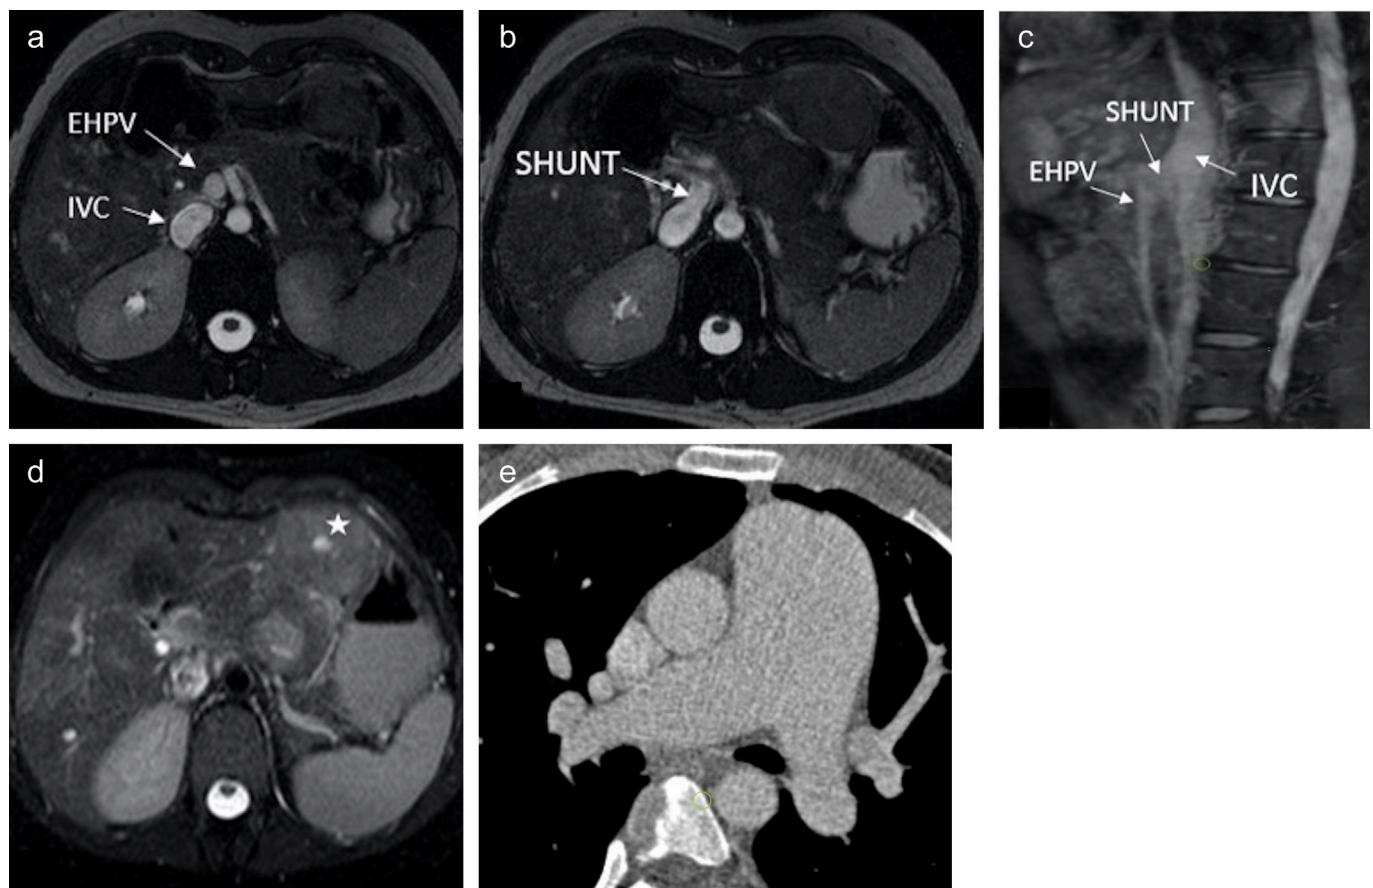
a-e. Type 1b Abernethy malformation with hepatic focal nodular hyperplasia and pulmonary hypertension. Consecutive axial balanced turbo field echo magnetic resonance (MR) images from inferior (a) to superior (b) show the EHPV draining into the retro hepatic IVC. No intrahepatic PV branches are seen. Sagittal MR angiography image (c) shows a shunt directly connecting EHPV to retro hepatic IVC. T2-weighted axial MR image (d) shows multiple hyperintense lesions (star), with hyperintense central scar in both lobes consistent with focal nodular hyperplasia. Axial contrast-enhanced computed tomography (CECT) image (e) of the same patient shows dilated pulmonary infundibulum (34 mm in diameter) suggesting pulmonary artery hypertension. EHPV, extrahepatic portal vein; IVC, inferior vena cava.
